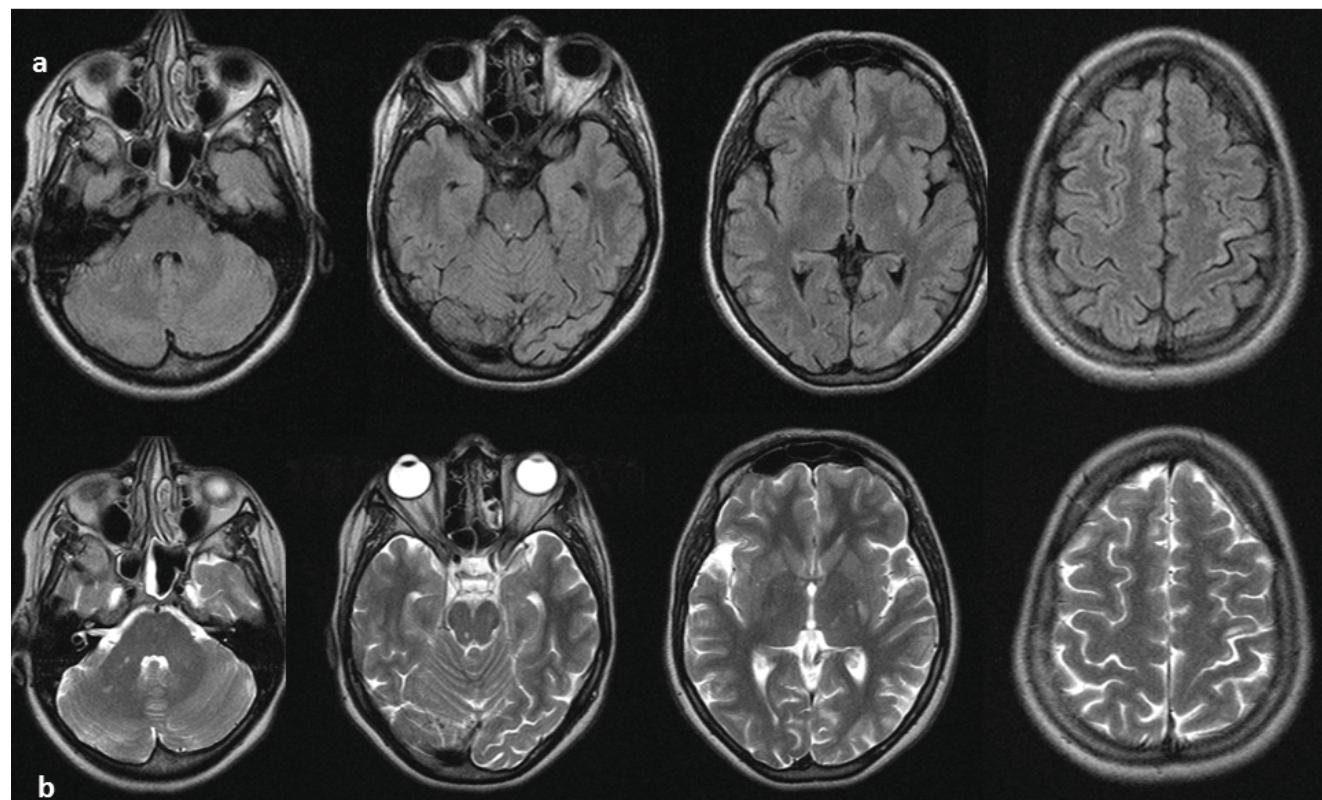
Brain MRI of the patient (a. FLAIR sequences; b. T2 sequences).
